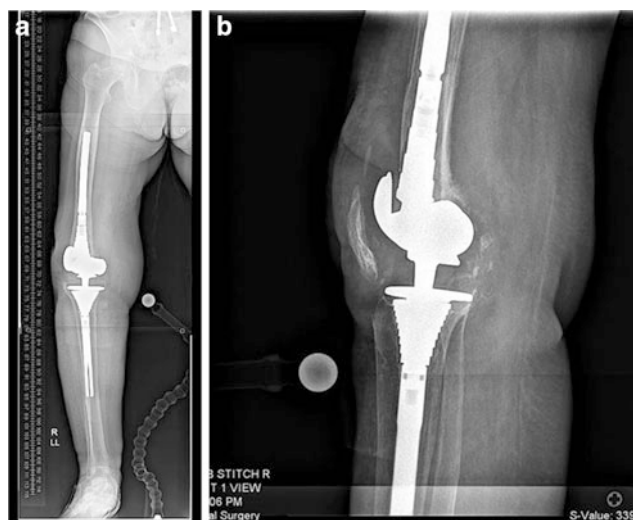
(a, b) Preoperative long-standing (hip to ankle) (a) anteroposterior (AP) and (b) lateral radiographs of the right knee demonstrating a revision TKA with femoral and tibial stemmed components and a highly constrained (rotating hinge) prosthesis. Note the reduced bone stock on both femoral and tibial sides from repeat TKA revision surgeries
